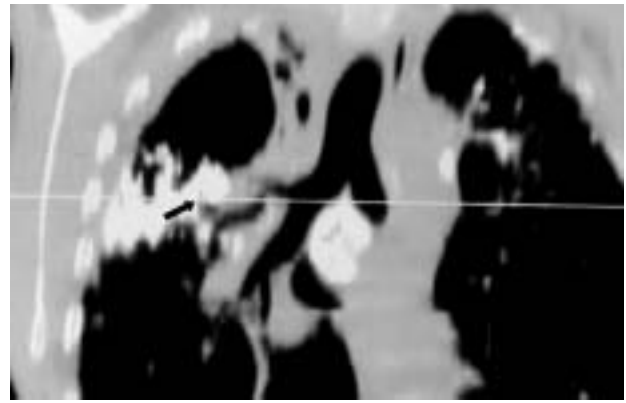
Helical computed tomography (coronal reconstruction), revealing the bronchololiths that originated from the parenchyma in close relationship with the bronchi (arrow) and the calcified lymph nodes.
